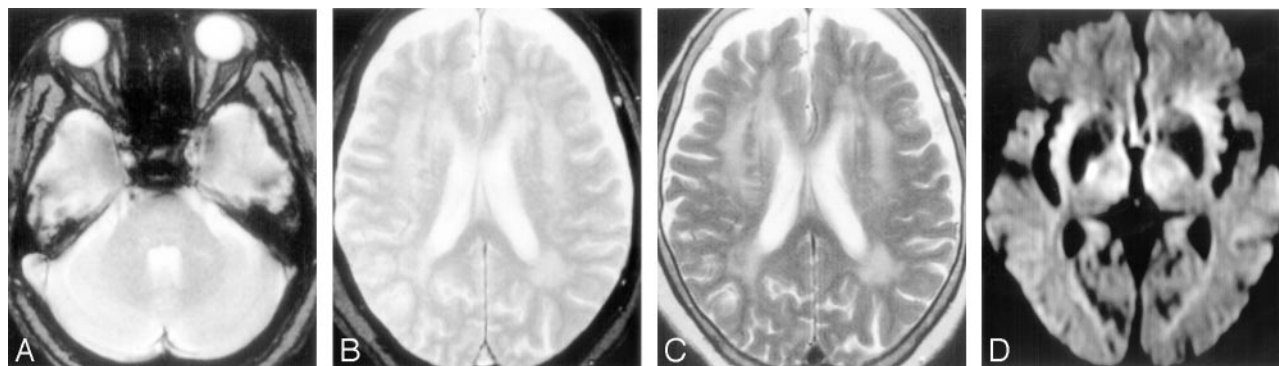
MR images obtained from a patient (85-year-old woman) with lacunar infarction in the right internal capsule after the occurrence of lacunar infarction in the right corona radiata. A and B, Initial T2*-weighted gradient-echo images (TR/TE, 800/26; flip angle, 20°) show no microbleeds. C, T2-weighted spin-echo image (TR/TE, 4500/112) shows advanced white matter hyperintensity. D, Diffusion-weighted image (single-shot echo-planar spin-echo sequence; TR/TE, 5300/135; b = 1000 mm²/s) obtained 23 months after the lacunar infarction shows a hyperintense lesion in the right internal capsule, consistent with acute infarction.
